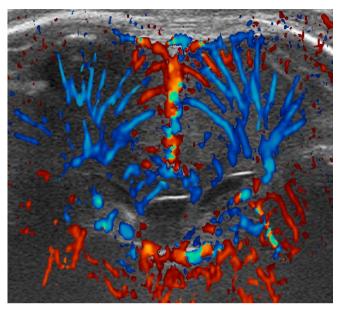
Cranial ultrasound image including colour Doppler. Coronal view at level of Monro, with 13 Mhz probe showing both hemispheres with microvessels in the periventricular white matter.
